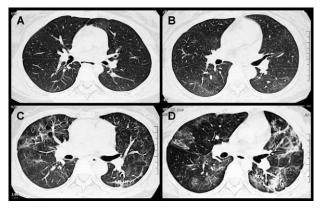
Typical HRCT scans through the middle lungs zones of SARS patients at 1 month after discharge. (A) No evidence of residual interstitial disease in Patient 11 (score = 0). (B) Mild disease (score = 1) in Patient 9. Note subtle ground-glass opacification at both superior segments of lower lobes. (C) Moderate disease (score = 2) in Patient 6. Note diffuse ground-glass opacification, thickening of interlobular septa, and mild traction bronchiectasis. (D) Severe disease (score = 3) in Patient 3. Note diffuse ground-glass opacification and consolidation, peribronchovascular thickening, and traction bronchiectasis with slight architectural distortion.
